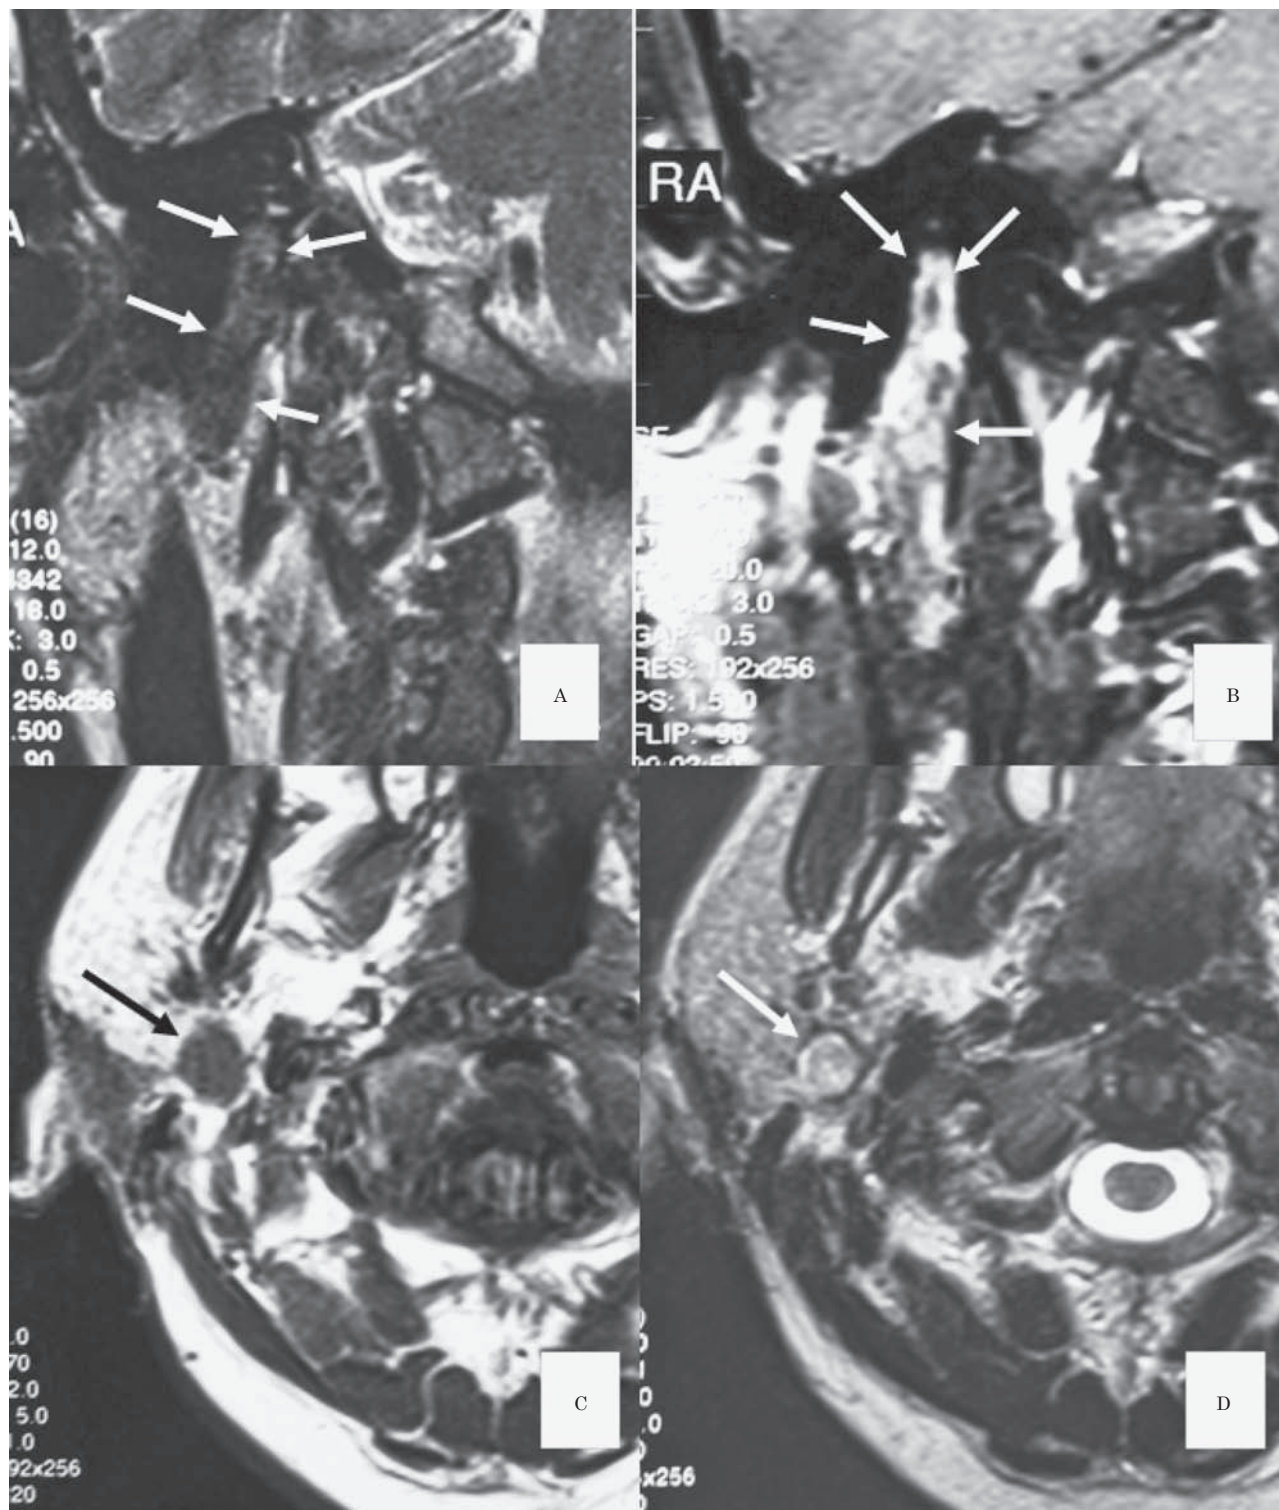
Coronal T2-weighted (A), and coronal postgadolinium T1-weighted (B) images obtained at the level of the stylomastoid foramina show foraminal expansion and thickening of the nerve (arrows) along the extratemporal portion through the parotid gland. The postgadolinium T1-weighted image (B) shows heterogenous contrast enhancement (arrows) of the thickened nerve. The pre-gadolinium axial T1-weighted image (C) shows the distal part of the neurofibroma in the right parotid gland (arrow) adjacent to the resection border. The axial T2-weighted image (D) depicts peripheral 'ring-like' and central 'dot-like' hyperintensity.
